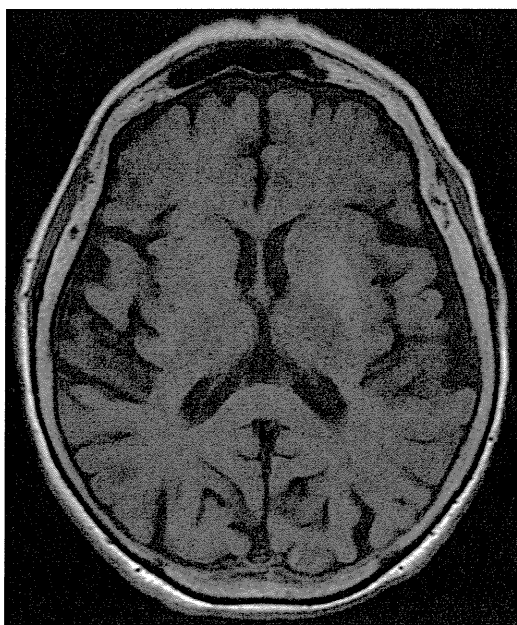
Axial T1-weighted MRI at the same level shows hyperintensity of the left lentiform nucleus.
